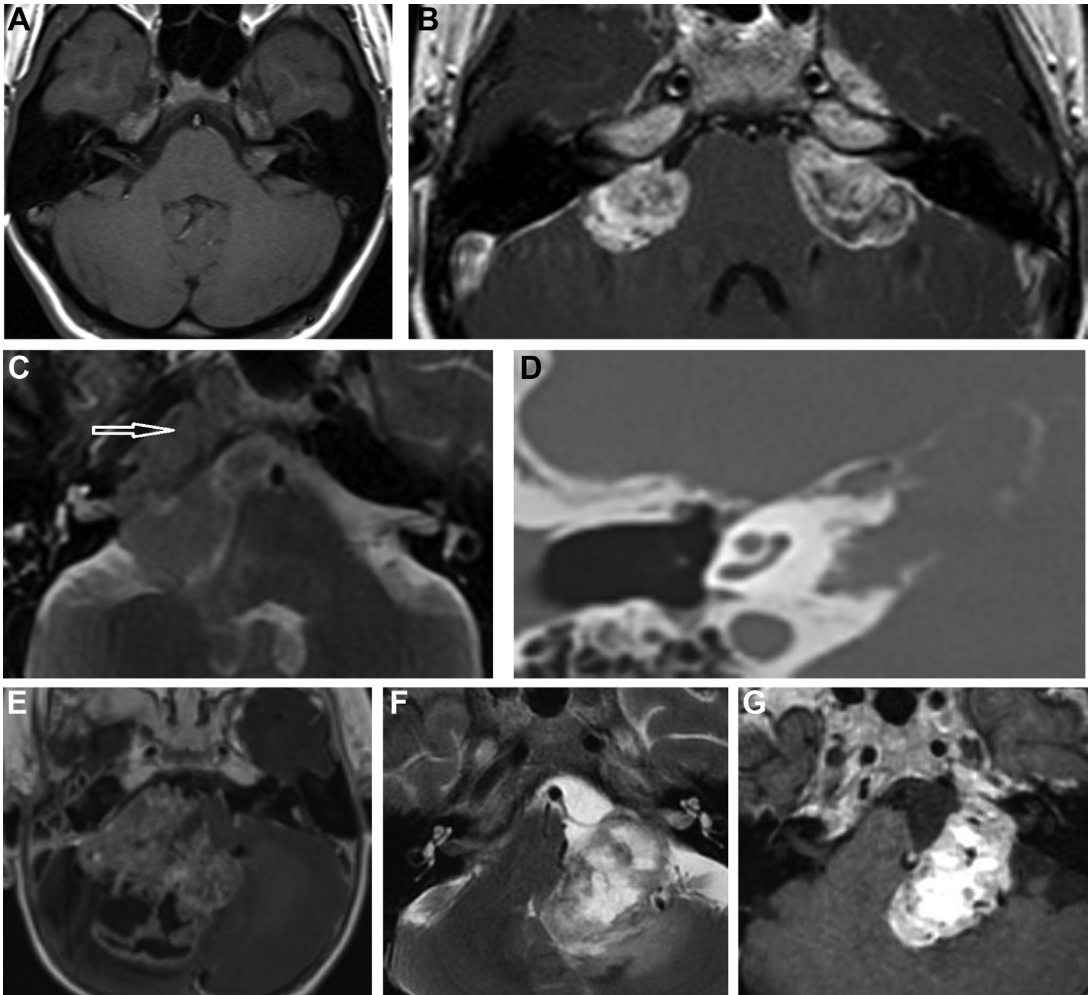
Pitfalls in the characterization of a CPA mass. (A) T1w axial image with patchy T1 high signal due to a low flow venous malformation. (B) Post-gadolinium T1w axial image with bilateral CPA lesions and additional meningeal enhancement secondary to leptomeningeal atypical rhabdoid teratoid tumor. (C) T2w axial image with CPA exophytic extension from a petrous apex (*arrow*) metastasis with the bony changes confirmed in the (D) CT study. (E) Post-gadolinium T1w axial image demonstrates CPA exophytic extension from an intra-axial GBM. (F) and (G) T2w and post-gadolinium T1w axial images demonstrating a hemangioblastoma extending exophytically into the CPA from a pial attachment to the lateral pons.
